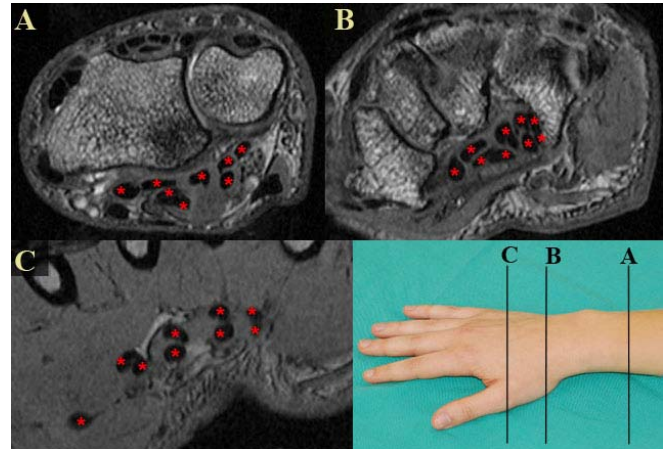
MR images, with flexor tendons identified by red dots within (B) and on either side of (A&C) the carpal tunnel. Only in the distal image in the hand (C), where the tendons align in pairs going to each finger (one to the thumb) and in two layers (deep and superficial), is tendon positive identification possible.
